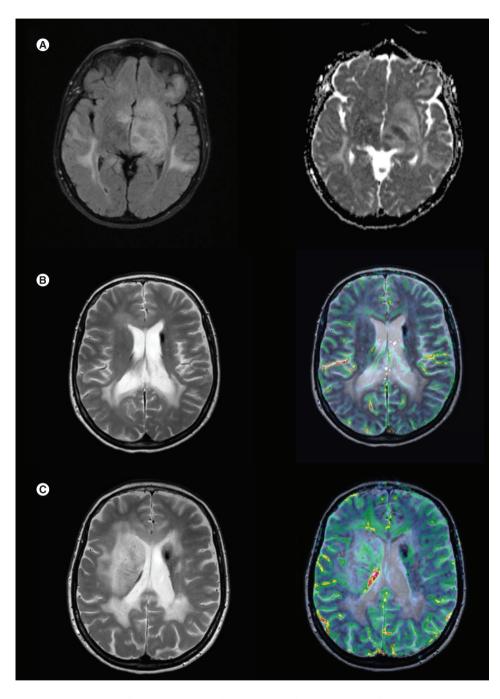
Axial slices from Case #2 MRI. (A) Axial slices from MRI with left: FLAIR, right: apparent diffusion coefficient. MRI after 2 weeks of confusion and right hemiparesis demonstrating diffuse T2/FLAIR hyperintense, nonenhancing lesion with mixed diffusion restriction in the left basal ganglia and subcortical white matter. (B) Axial slices from MRI with left: T2, right: cerebral blood volume. Surveillance imaging off treatment demonstrated bulky T2 hyperintensity in the splenium of the corpus callosum without enhancement or elevated cerebral volume. (C) Imaging of frank recurrence with large, bulky T2/FLAIR hyperintensity in the right basal ganglia and subcortical white matter without definitive enhancement but with markedly elevated cerebral blood volume.
